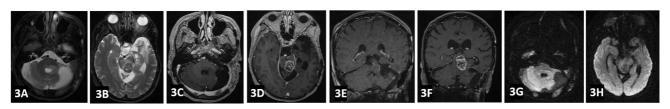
Forty-five days postsurgery magnetic resonance imaging (MRI). (A, B) Axial T2-weighted MRI. Axial (C, D) and coronal (E, F) MRI and axial diffusion-weighted imaging (G, H) revealed a large recurrent heterogeneous rim-enhancing mass within the dorsal left midbrain measuring $3.1 \times 2.3 \times 2.3$ cm, with resultant mass effect on the cerebral aqueduct and inferior third ventricle.
